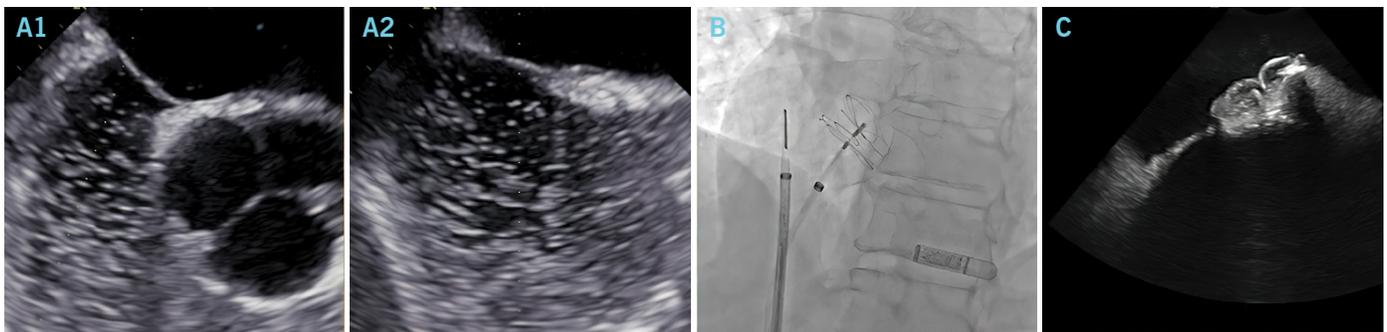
A1 and A2 Transesophageal echocardiogram with bubble study, showing PFO with right to left shunt. B) Fluoroscopy showing an intracardiac echocardiogram catheter and a PFO occluder device during a procedure. C) Intracardiac echocardiogram images showing the PFO closure device after deployment.
